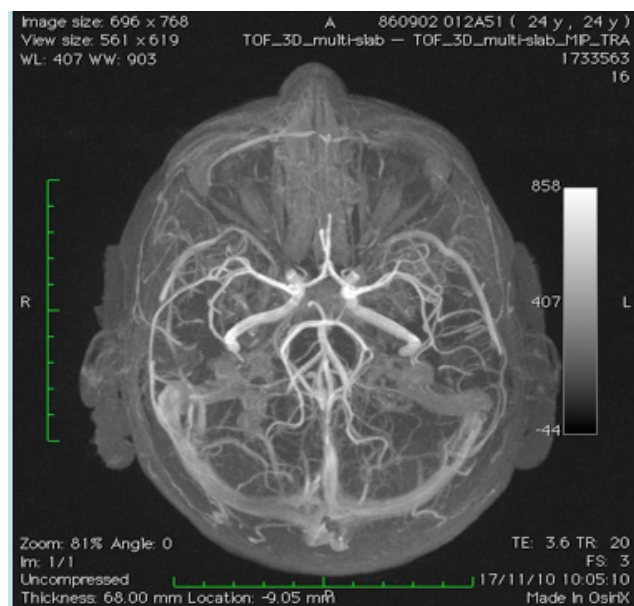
Magnetic resonance imaging with angiography of the circle of Willis and its afferent arteries. No arteriovenous malformations are detected.
